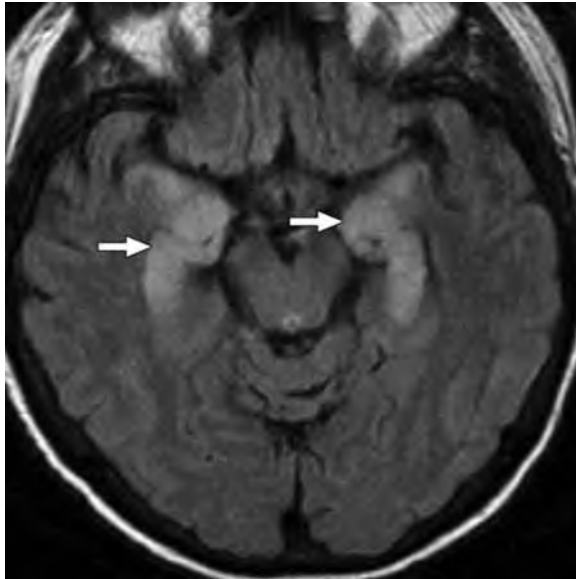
Magnetic resonance image showing bilateral medial temporal lobe involvement (arrows) in a hematopoietic stem cell transplant recipient. (Courtesy Alexander Freeman, National Institute of Allergy and Infectious Diseases.)
